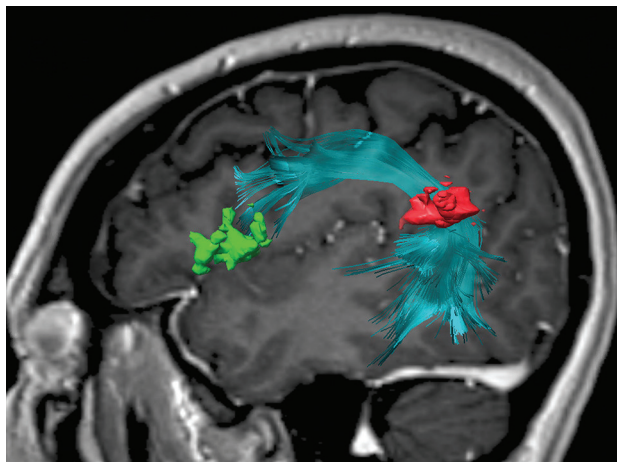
Sagittal 3D-FLAIR image with a superimposed diffusion tensor image of the arcuate fasciculus between the inferior frontal gyrus (pars opercularis and pars triangularis) (green) and the angular gyrus (red). The frontotemporal segment of the arcuate fasciculus connects the Broca area at the inferior frontal gyrus with the Wernicke area more posteriorly, traditionally at the posterior-superior temporal gyrus. However, this connection is variable, and in this case, it is at the angular gyrus/posterior superior temporal area. The authors regret the error.
